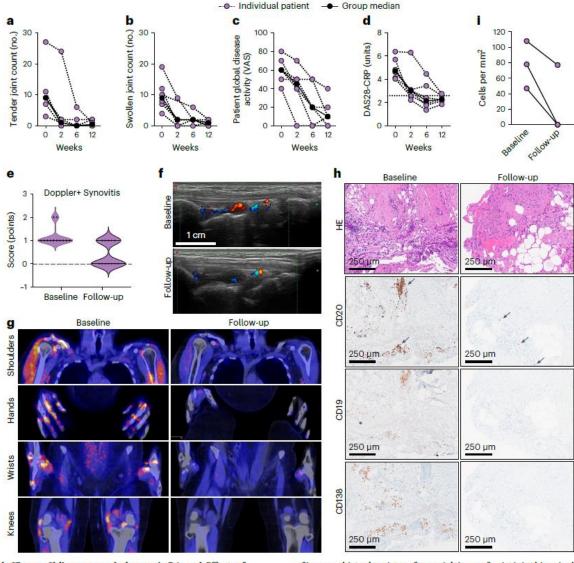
Clinical efficacy of blinatumomab therapy in RA. a–d, Effects of blinatumomab on tender joint count (a), swollen joint count (b), patient global disease activity (VAS, O-100) (c) and DAS28 (d). Dotted horizontal line in d shows cut-off for remission (2.6); n=6 individual patients. e, Quantification of PD before (baseline) and after (follow-up) therapy with blinatumomab; n=12 joints from n=6 individual patients. f, Example of decrease in PD signal in the wrist before and after blinatumomab (patient 5). g, Example of FAPI-PET-CT before and 3 months after therapy with blinatumomab (patient 2). h, Example
